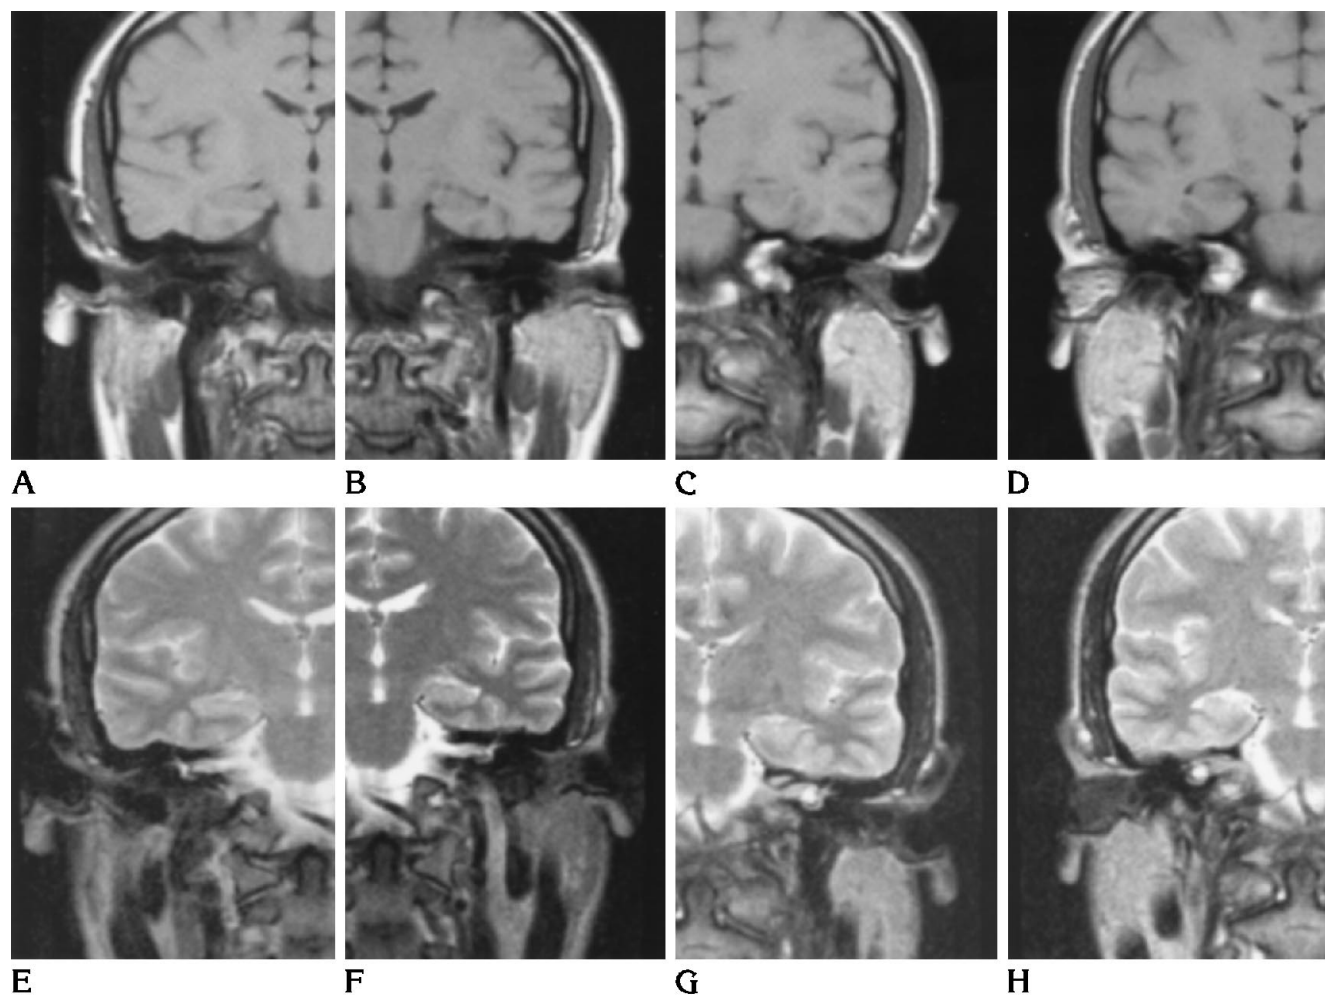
T1- and T2-weighted images of packing materials in the external auditory meatus in volunteers. The T1-weighted images are of bismuth and iodoform paraffin paste (A), aqueous betadine gauze (B), calcium sodium alginate (C), and triiodocortyl cream (D). E through H show corresponding T2-weighted images.
